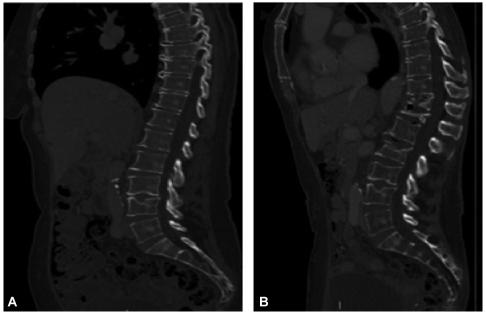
Computed tomographic scans at baseline in August 2017 (A) and scans showing somatic vertebral collapses in October 2017 (B).
